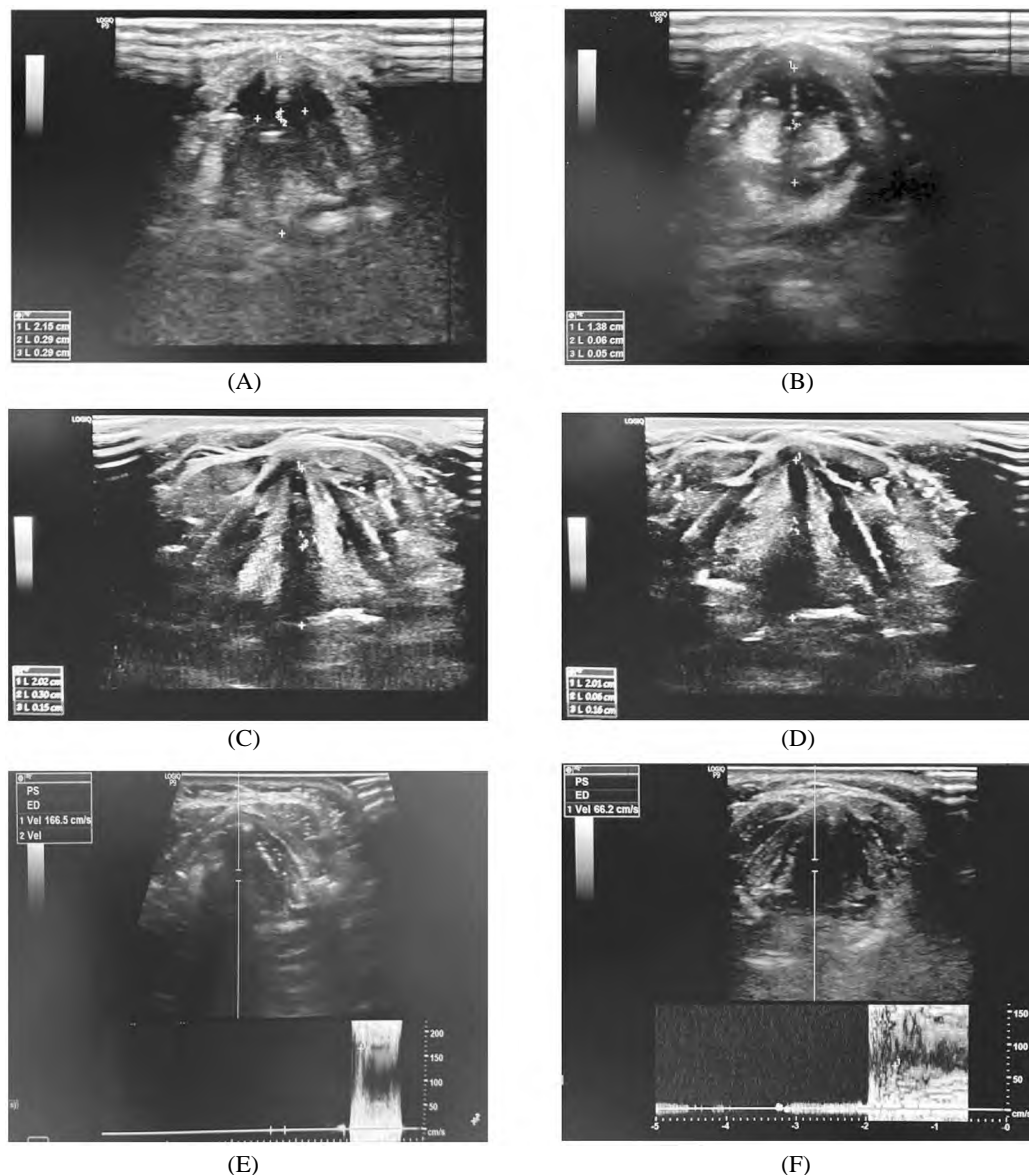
A 21 years old male patient, presented with thyroid cancer, total thyroidectomy was done and he experienced hoarseness of voice 10 days later. Laryngeal ultrasonography was done and positive result was reported of immobile left VF. Distance of left VF from midline at both valsalva and active inspiration was 1.5 mm. While the right VF was mobile with distance 0.6 mm from midline at valsalva, it was 3 mm during active inspiration. VFDV before thyroidectomy was 166 cm/s and it was 66 cm/s after thyroidectomy. The normal VFs movement in a male has thyroid cancer before thyroidectomy during valsalva maneuver and active inspiration, (A) Showing abduction of both VFs normally during active inspiration, the right VF abduction by 2.9 mm from midline and the left VF by 2.9 mm. (B) Showing adduction of both VFs normally during valsalva maneuver, the right VF adduction by 0.6 mm from midline and the left VF by 0.5 mm. The VFs movement in a left VF paralysis male after thyroidectomy during valsalva maneuver and active inspiration, VFDV before and after thyroidectomy, (C) Showing fixed left VF with 1.5 mm from midline and abduction of right VF during active inspiration by 3 mm. (D) Showing fixed left VF with 1.5 mm distance from midline and adduction of right VF during valsalva maneuver by 0.6 mm. (E) Showing VFDV before thyroidectomy measuring 166 cm/s. (F) Showing VFDV after thyroidectomy measuring 66 cm/s. Laryngoscopy confirmed left vocal cord paralysis.
